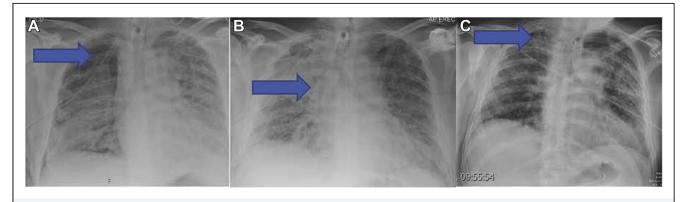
(A) A preprocedure chest radiograph showing right-sided pneumothorax. (B) A postprocedure chest radiographs demonstrating the endobronchial valve in situ followed by (C) a post-drain removal radiograph highlighting the edge of the right upper lobe.
